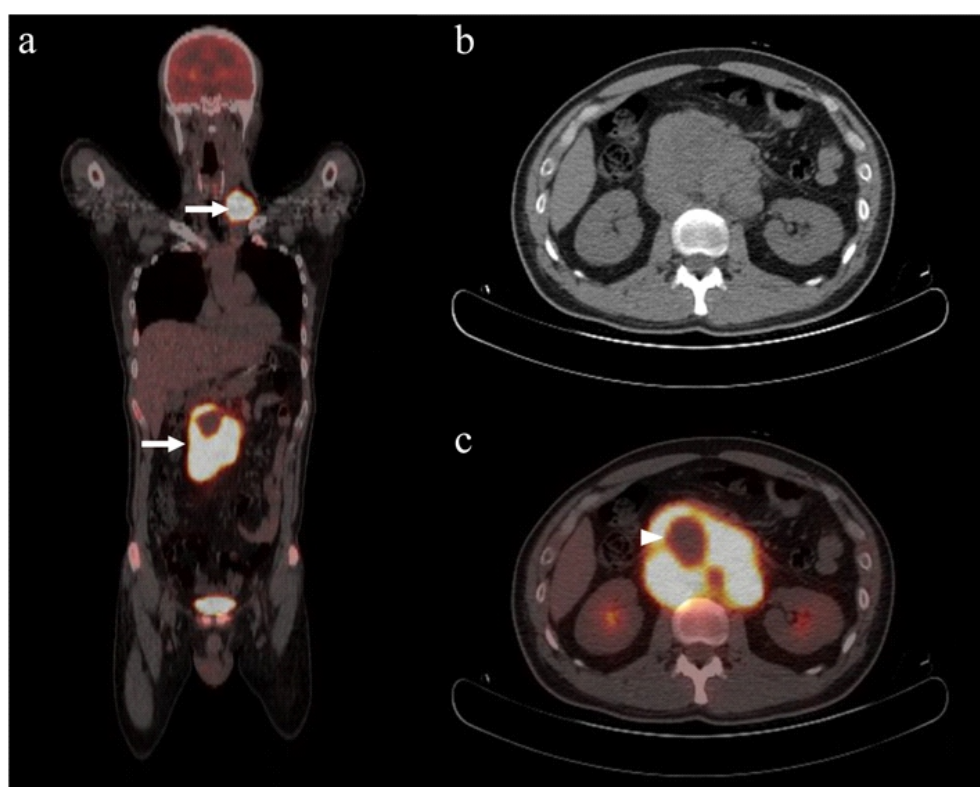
Assessment of tumor necrosis on ^{18}F -FDG PET/CT imaging. A 45-year-old male patient with DHL presented with tumor masses localized in the retroperitoneum and left neck. The coronal ^{18}F -FDG PET image (a) depicts the extent of the tumors (white arrows). The axial CT (b) and fused ^{18}F -FDG PET/CT (c) images further elucidate the presence of hypometabolism areas within the tumor masses located in the retroperitoneum (white arrowhead), indicative of necrotic tissue.
